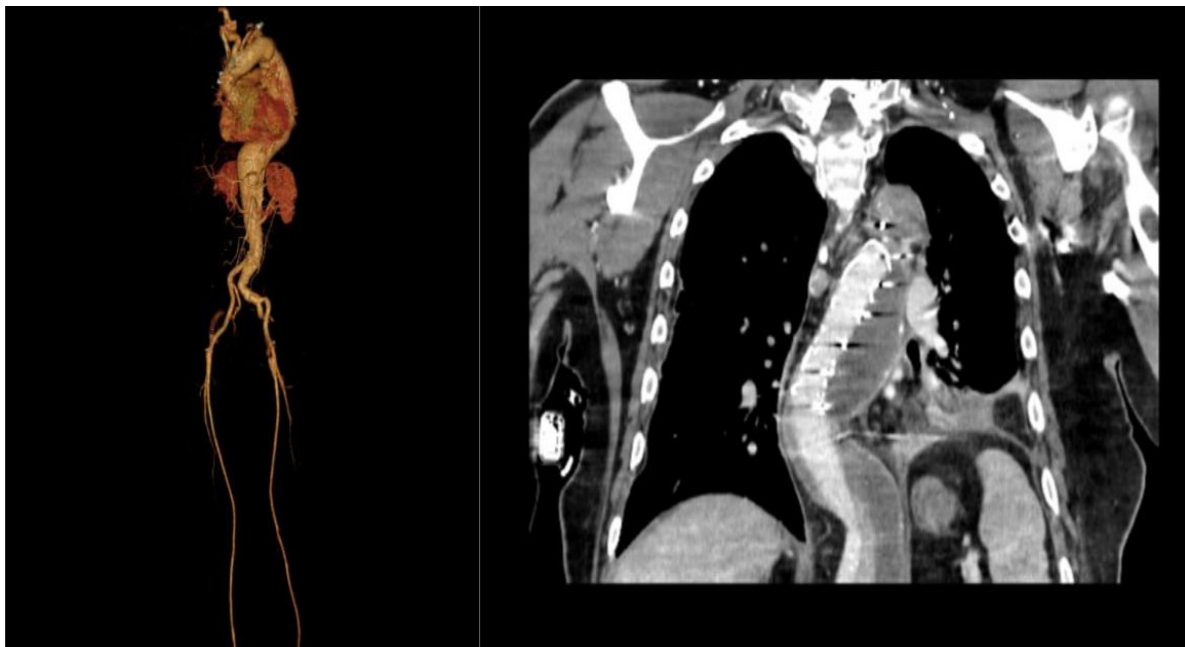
(a) Three-dimensional reconstruction demonstrating aneurysmal dilatation of the thoracic and abdominal aorta. (b) Postoperative CT images following FET graft placement, demonstrating graft position and aortic reconstruction.
